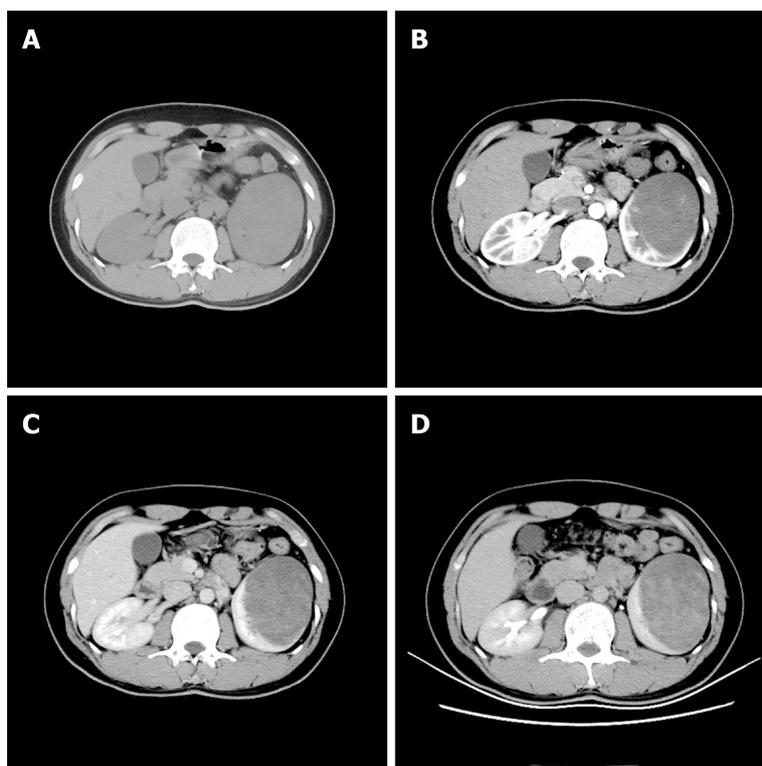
Computed tomography. A: Non-enhanced computed tomography image showing a round, well-defined, and mixed mass; B: Enhanced computed tomography image during the corticomedullary phase; C: Nephrographic phase; D: Delayed enhancement of the solid part and no enhancement of the cystic part.
